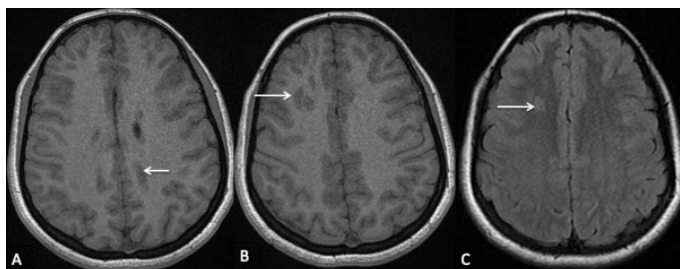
Young adolescent girl, 18 years old, consulted for drug-resistant generalized epilepsy 4A) MRI with T1 SEQUENCES 4B) FLAIR sequence 4C) Presence of nodular lesions, isointense to the SG at the different sequences, in the periventricular area.
